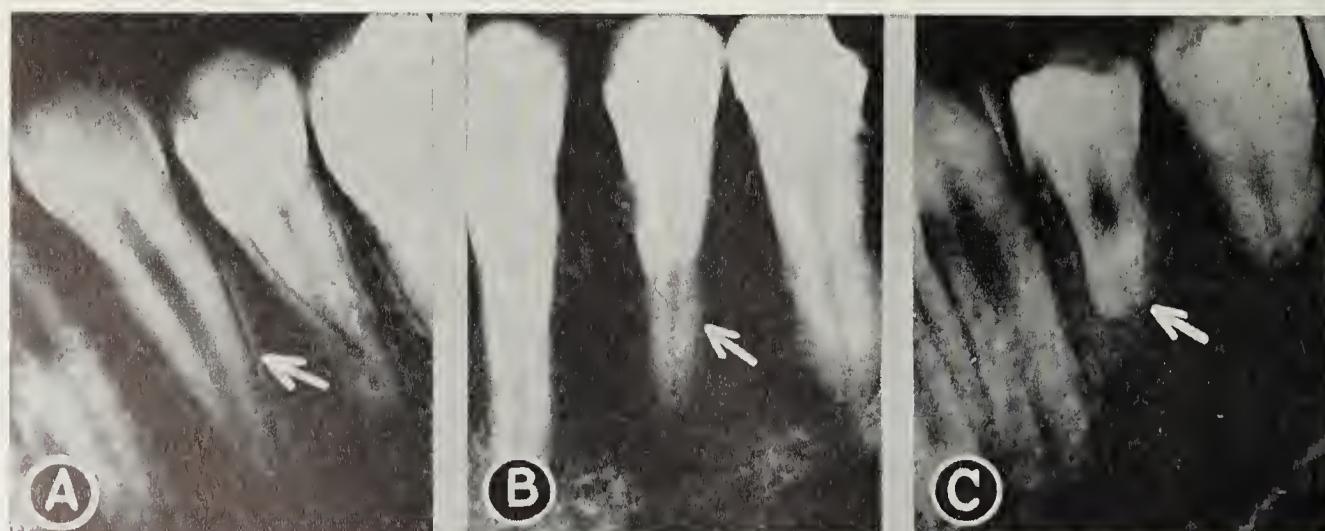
Photographs of x-ray films of teeth comparing those of the normal individual with those of patients with hyperparathyroidism and hypoparathyroidism. (A) The teeth of a normal individual. Note the presence of the lamina dura (arrow). (B) The teeth of a patient with hyperparathyroidism. Note the absence of the lamina dura (arrow). (C) The teeth of a patient with hypoparathyroidism. Note the blunted ends of the teeth (arrow).
